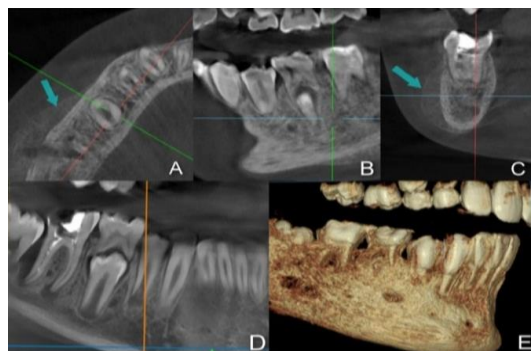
CBCT slices A) axial B) sagittal C) cross-sectional D) reconstructed panoramic E) reconstructed 3D showing laminated appearance of new periosteal bone formation in the inferior margin of mandible and along the buccal cortex. 4 A shows breach in the buccal cortex.
